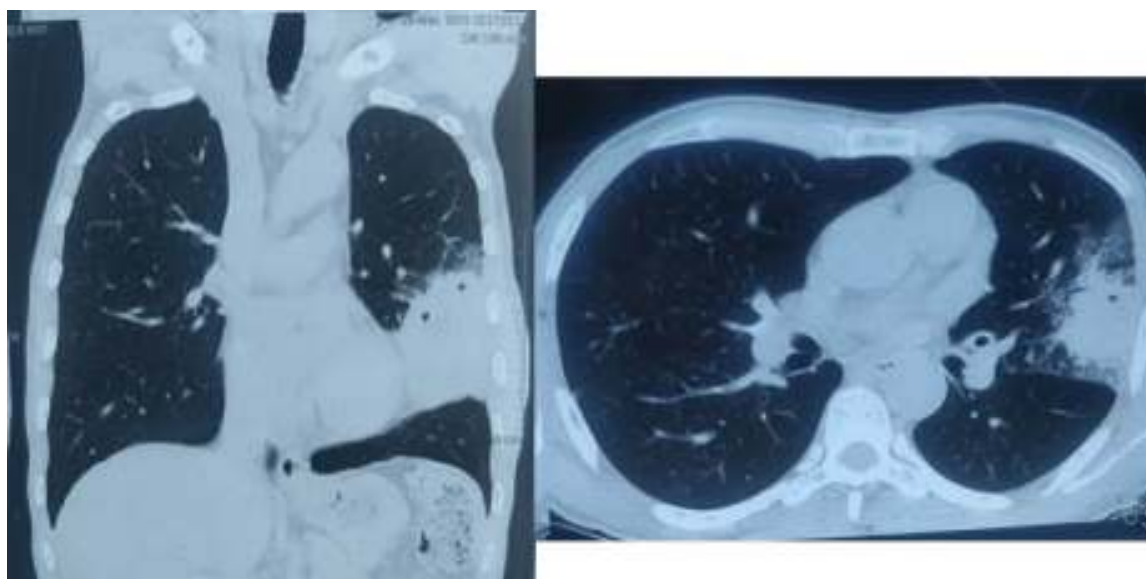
CT thorax showing Left lower lobe cavitating nodule
